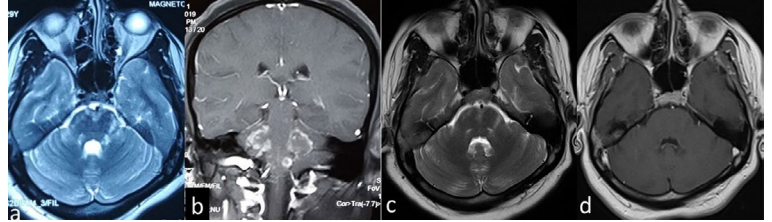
Axial T2WI brain MRI (a) shows multiple hyperintense lesions in pons and middle cerebellar peduncle. Post contrast coronal T1WI (b) shows patchy and curvilinear enhancement mimicking CLIPPERS. Follow up MRI: Axial T2WI (c) and post contrast T1WI (d) shows reduced size and number of the lesions and no enhancement.
